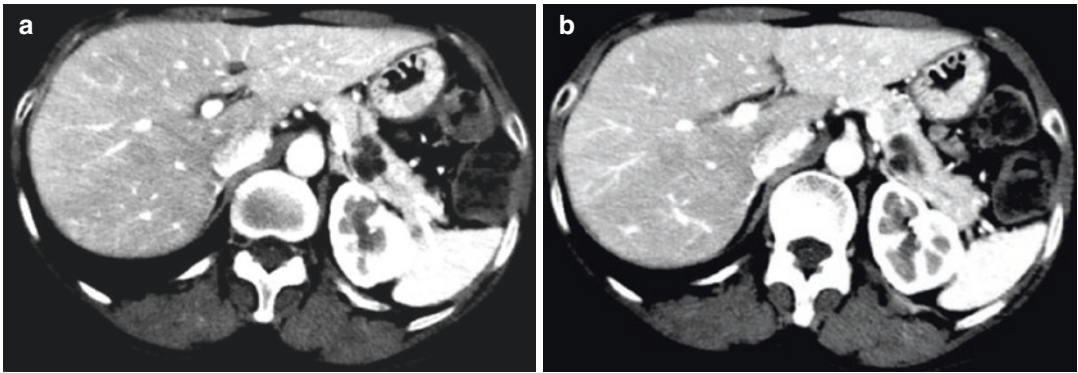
(a, b) CT image showed a cystic mass in the distal pancreatic lesions
